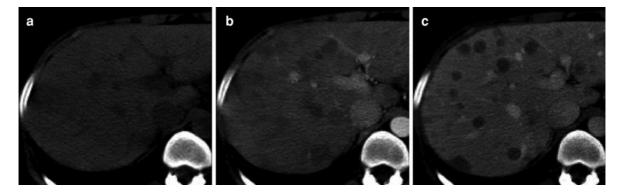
Hypovascular metastatic liver lesions from cutaneous melanoma. a Transverse unenhanced CT image demonstrates subtle heterogeneous appearance of the liver without discrete lesions. b Corresponding contrast-enhanced CT image during
